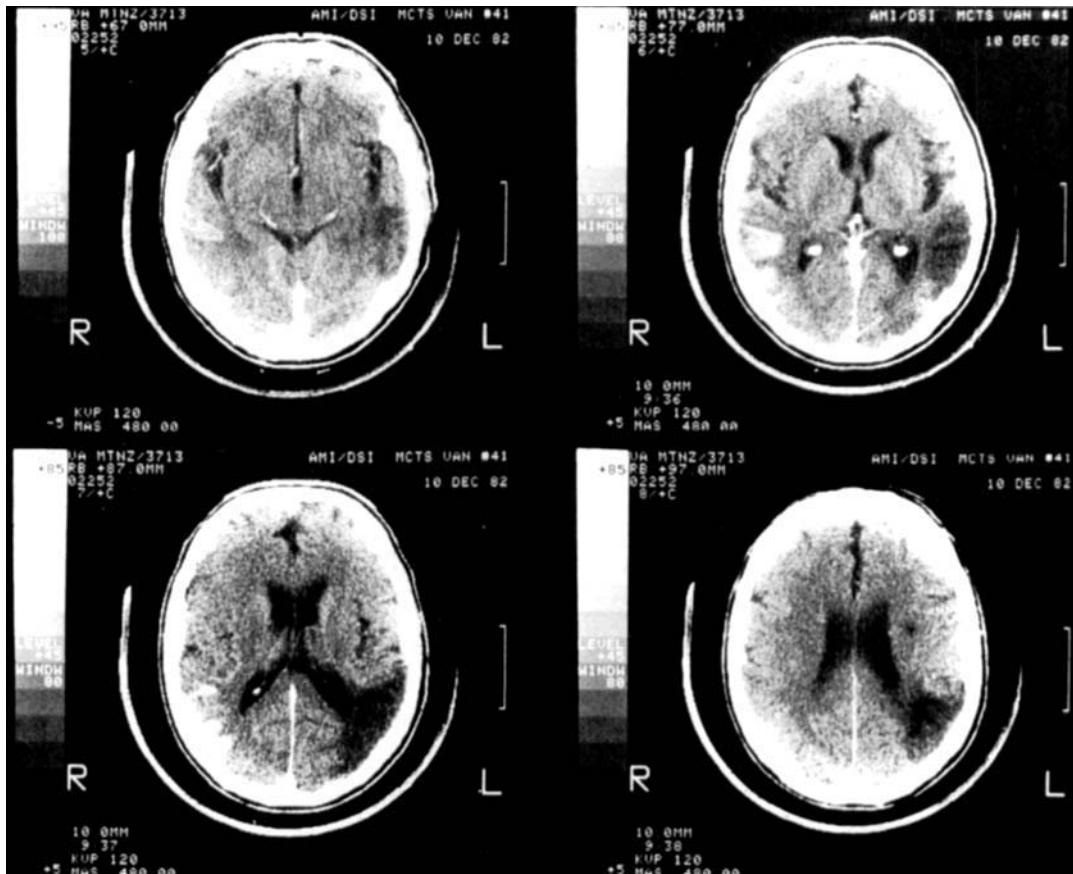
Computed tomography with contrast enhancement shows an old infarct in the left temporoparietal region and an acute enhanced infarct in the right temporoparietal region.
